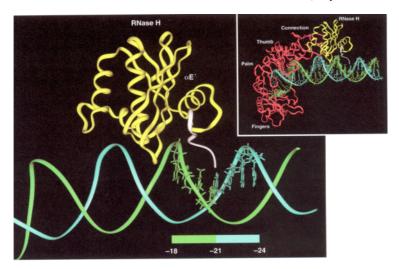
Positioning of the RNase H domain within duplex DNA of HIV-1 RT to account for azidophenacyl-mediated cross-linking to template and primer nucleotides. All structural features of HIV-1 RT other than the C-terminal p66 RNase H domain have been omitted for clarity. Within the RNase H domain, the last structural element, α-helix E', has been indicated for reference. The white portion represents C-terminal RNase H residues. Native residues 559 and 560 along with the cysteine introduced at position 561 modelled onto the published X-ray structure are shown in white. Template and primer nucleotides are green and blue, respectively, as are the nucleotides to which azidophenyl-mediated cross-linking could be achieved
